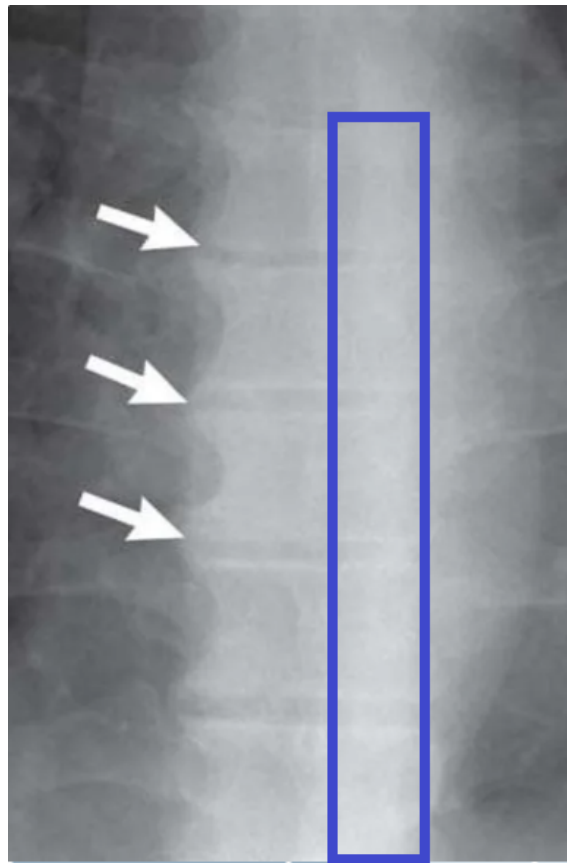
Anterior-posterior x-ray of 51-year-old man with DISH showing, with white arrows, areas of protruding disk material and, with the blue rectangle, the location of the ossifications [Adapted from [36]].
